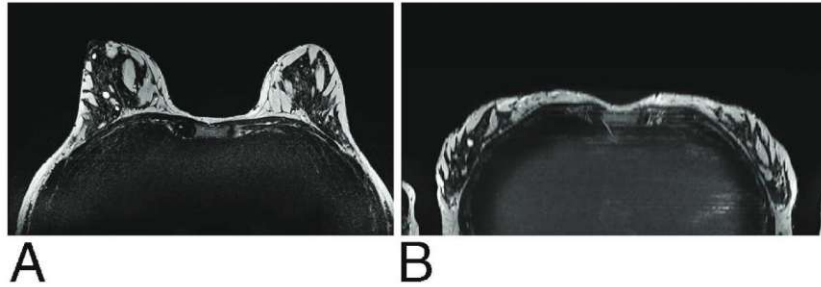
Comparison of breast tissue distribution in prone (A) vs. supine MR images (B) in the axial plane (adapted from [43]).
